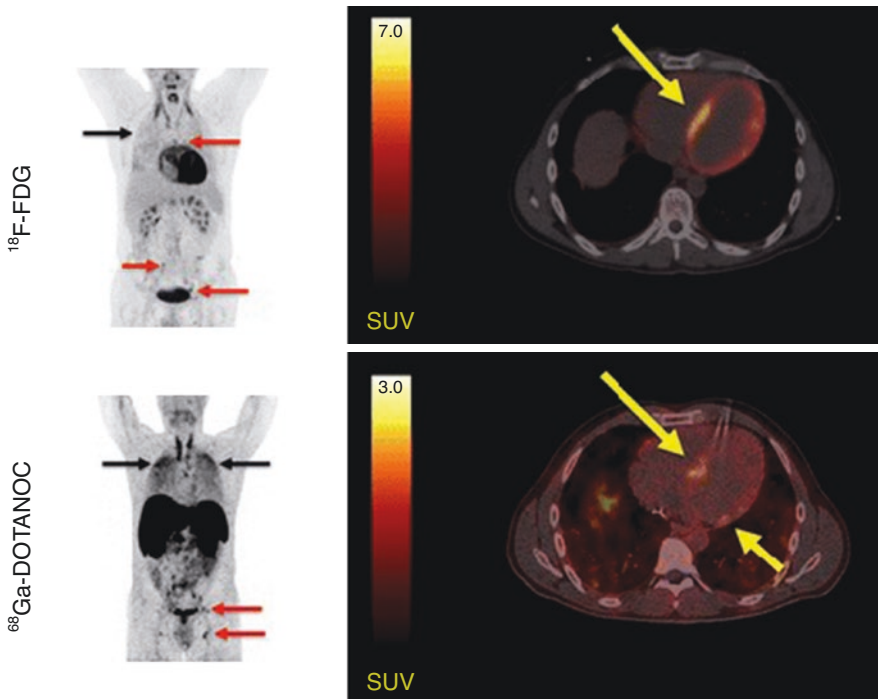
Patient with cardiac sarcoidosis in which the ^{18}F -FDG PET/CT was inconclusive due to insufficiently suppressed physiological ^{18}F -FDG uptake by the myocardium. (Left panel) MIPs showing a patient with dilated cardiomyopathy and multiple ^{18}F -FDG and ^{68}Ga -DOTANOC avid lymph nodes (red arrows) both above and below the diaphragm. Furthermore, there is massive and diffusely increased activity in the lung parenchyma (black arrows) reflecting active pulmonary sarcoidosis. (Right panel) The top image raises suspicion for cardiac involvement with a region of focal on diffuse pattern of ^{18}F -FDG uptake in the PET/CT transaxial slices (SUVmax 21 at the septum). This scan was considered non-conclusive by a reviewer panel. In contrast, all reviewers rated the ^{68}Ga -DOTANOC uptake (SUVmax 2.8, target-to-background 3.04) in the septum pathological (bottom). The patient was treated with corticosteroids and recovered. *MIP* maximum intensity projections. (Reproduced with permission from Gormsen LC, et al. *EJNMMI Res.* 2016;6:52)
